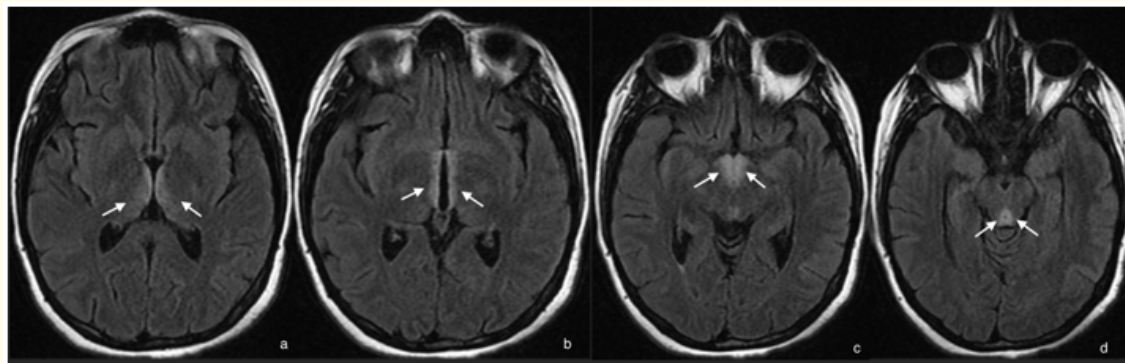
MRI in axial sections in Flair sequence shows bilateral thalamic hyperintensity (a) around the third ventricle (b) in the mammillary bodies (c) and periaqueductal grey matter (d) concordant with a Wernicke’s encephalopathy.
